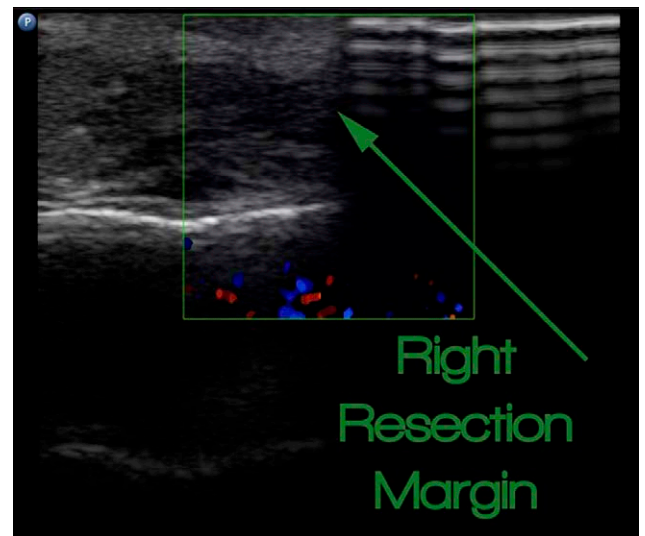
CDUS of the soft tissues beyond the right resection margin. CDUS indicates Color Doppler Ultrasound.
